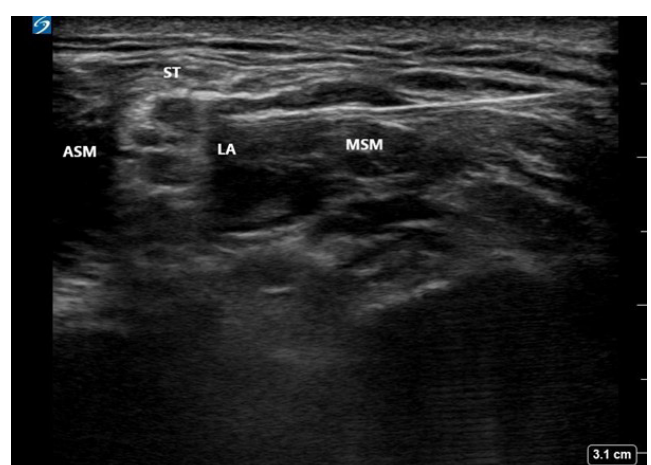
Ultrasound image after superior trunk block. ASM: anterior scalene muscle, LA: local anesthetics, MSM: middle scalene muscle, ST: superior trunk.
